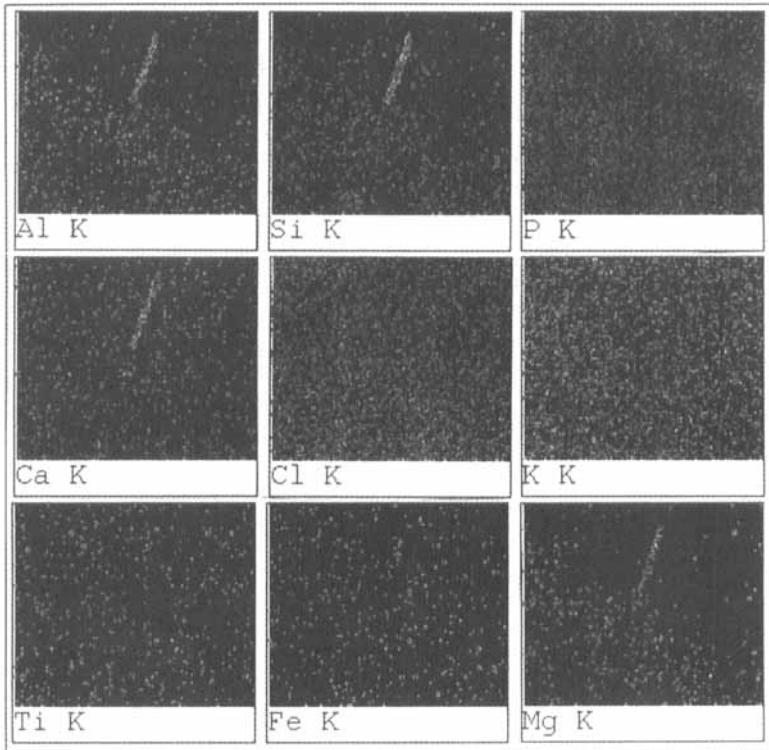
Elemental maps acquired by energy-dispersive X-ray analysis for constituents of fiber and lung tissue structures shown in Figure 4a. Compare with data obtained for refractory ceramic fiber RCF1a in tissue for 30 days (Fig. 1b). (See Color Plate II).
